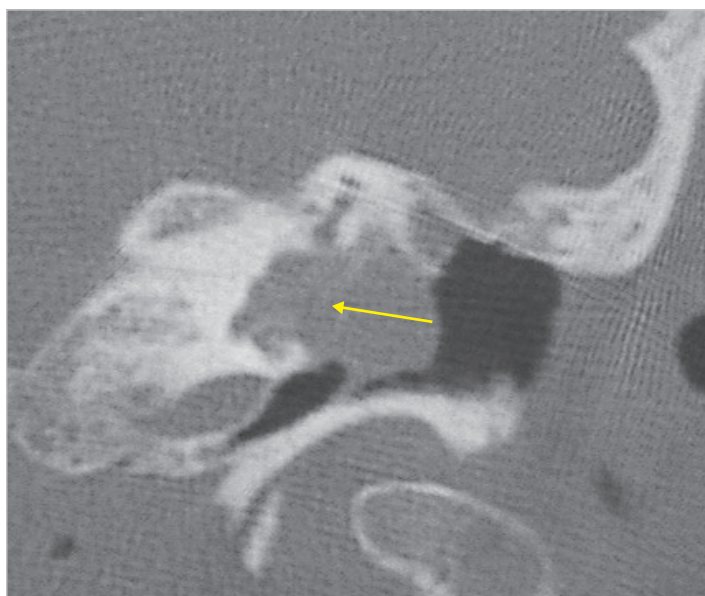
CT scan of the same case, coronal section. The medial extension of the cholesteatoma severely eroding the cochlea can be appreciated (*arrow*).
